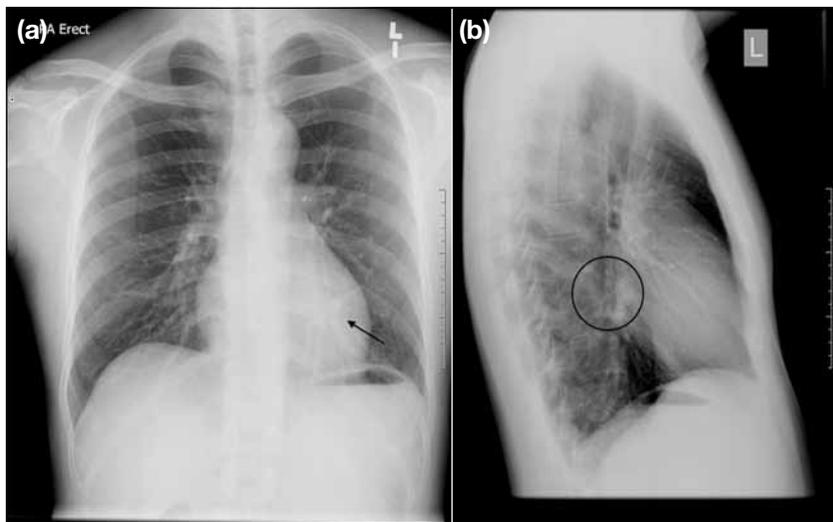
Chest radiographs of a patient with anomalous systemic arterial supply to the normal basal segments of the lower lobe of the lung. (a) Posterior-anterior projection demonstrating an approximately 2x4-cm shadow at the left retrocardiac region (arrow), with adjacent dilated tubular structures, suspicious of feeding arteries and draining veins; and (b) left lateral projection confirming the observations in the posterior-anterior projections (circle).
